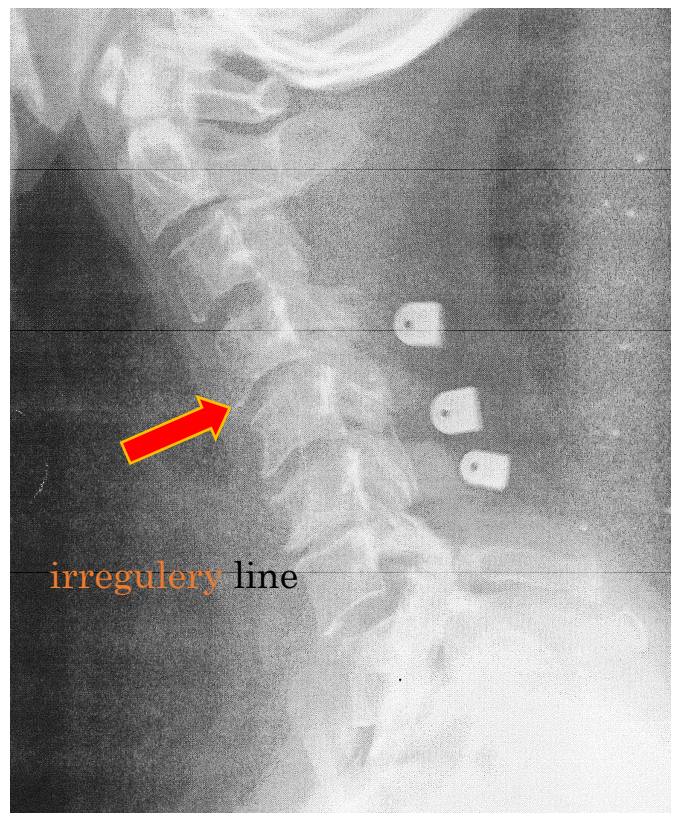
Case 2, X-ray image after two months of treatment:
